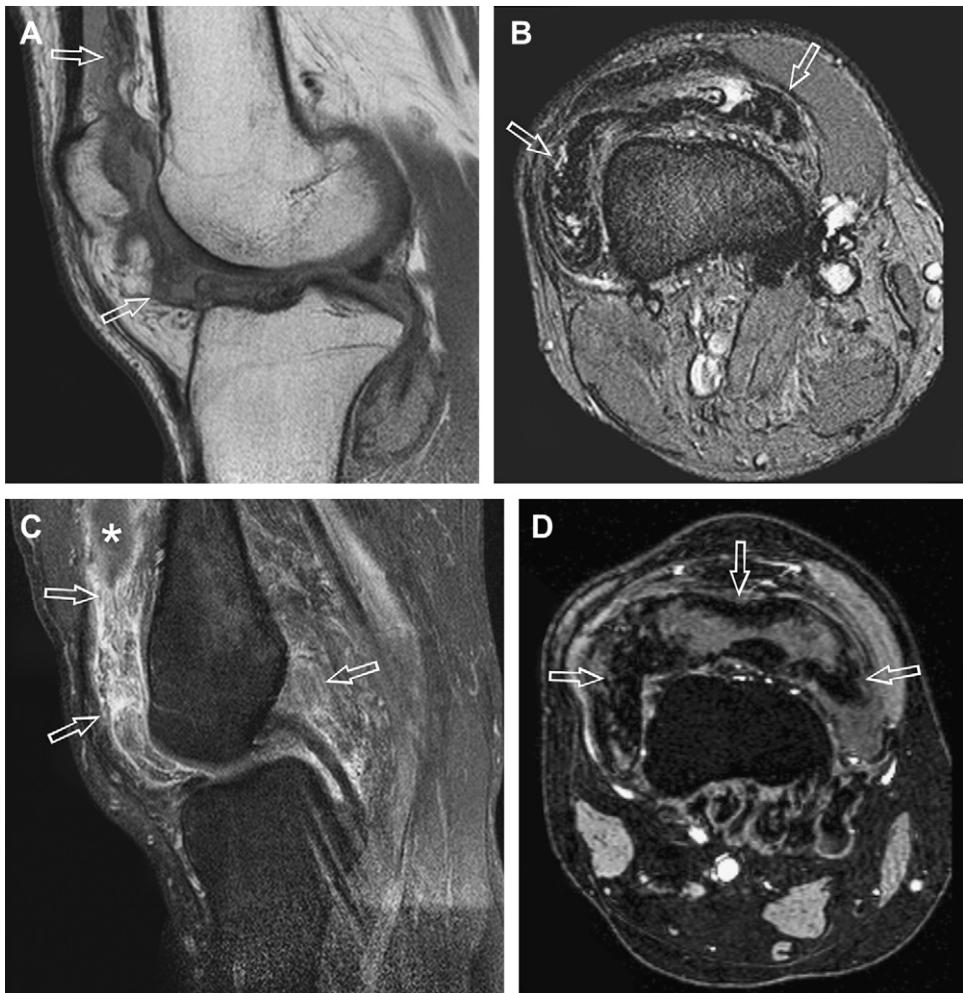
PVNS. Diffuse PVNS in a 37-year-old woman with pain and swelling of right knee for 1 year. (A) Sagittal proton density-weighted (TR/echo time [TR/TE], 2000/21.3) and (B) axial fat-saturated T2W (TR/TE; 3800/105) MR images show diffuse low-signal intensity thickening (arrows) of the synovium. (C) Sagittal fat-saturated T1W postcontrast image shows diffuse synovial enhancement (arrows) throughout the knee. Note the peripheral enhancement around the joint effusion (asterisk). (D) Axial gradient echo imaging (TR/TE, 50/12) in a 26-year-old man with chronic knee pain shows accentuation (blooming) of the low signal of the thickened synovium (arrows) resulting from hemosiderin deposition.
